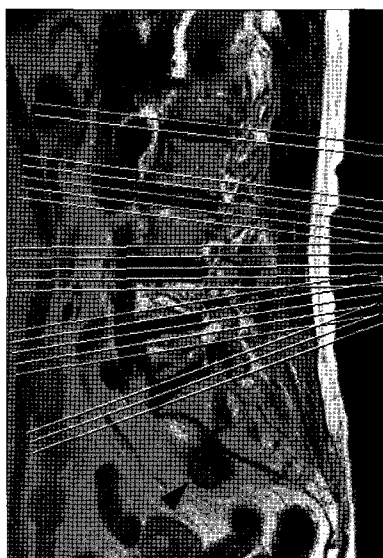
Retrograde reviewing of lumbar MRI showing presacral mass (arrow) which was difficult to distinguish from the pelvic content.
